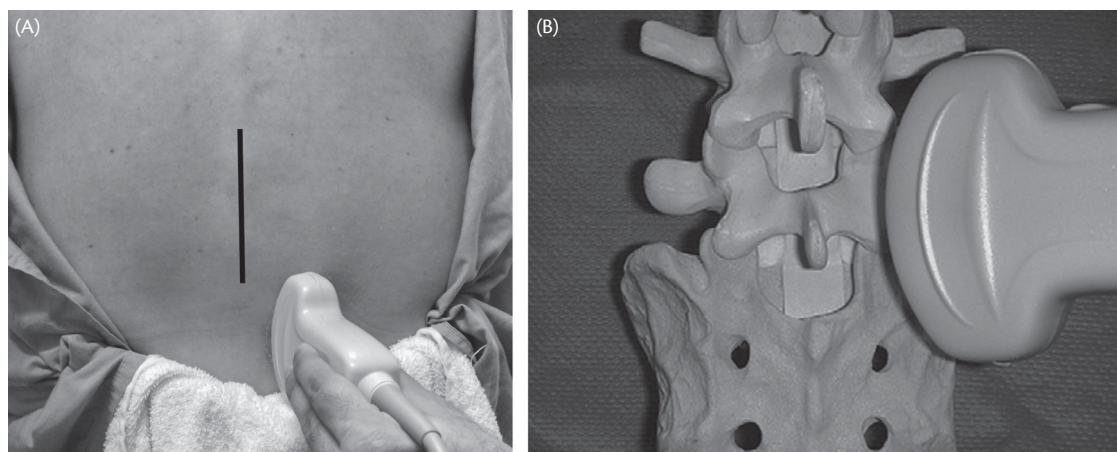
(A) Ultrasound probe orientation in paramedian sagittal oblique position (PSO plane) (B) Ultrasound probe orientation in PSO plane in relation to spine. (B) This figure was published in *Anesthesiology Clinics*, Volume 26, Jose Carlos Almeida Carvalho, Ultrasound-Facilitated Epidurals and Spinals in Obstetrics, pp. 145–158, Copyright (2008).
